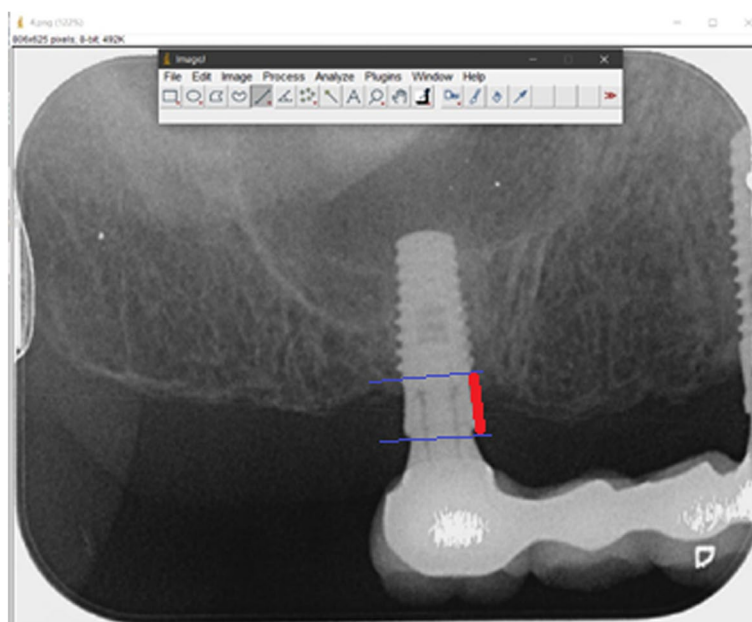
MBL measurement with periapical radiography
